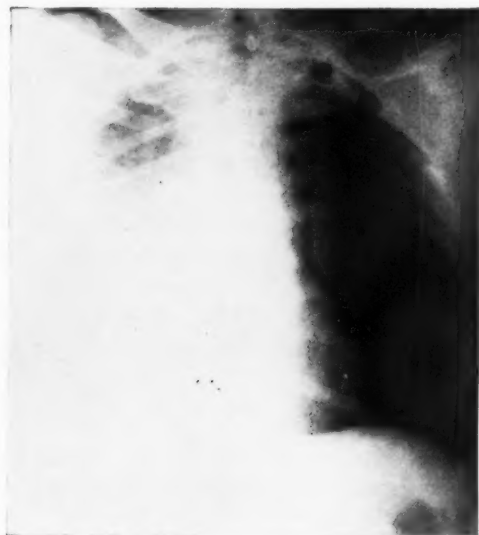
(portable roentgenogram). Acute collapse of the right lung four days following subtotal gastrectomy. The shadow of increased density appears to involve the greater portion of the right lung. The heart and mediastinum are displaced to the right. The rib spaces are questionably narrowed. The position of the diaphragm is not definite. A roentgenogram taken five days later showed the lung considerably re-expanded.
